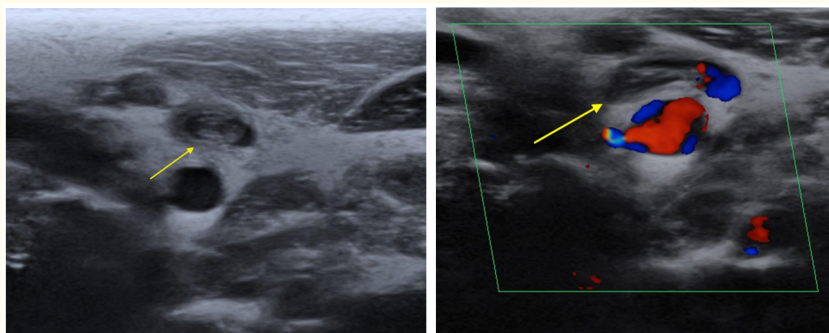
Cervical color ultrasound doppler. Left jugular vein filling defect (arrow).
